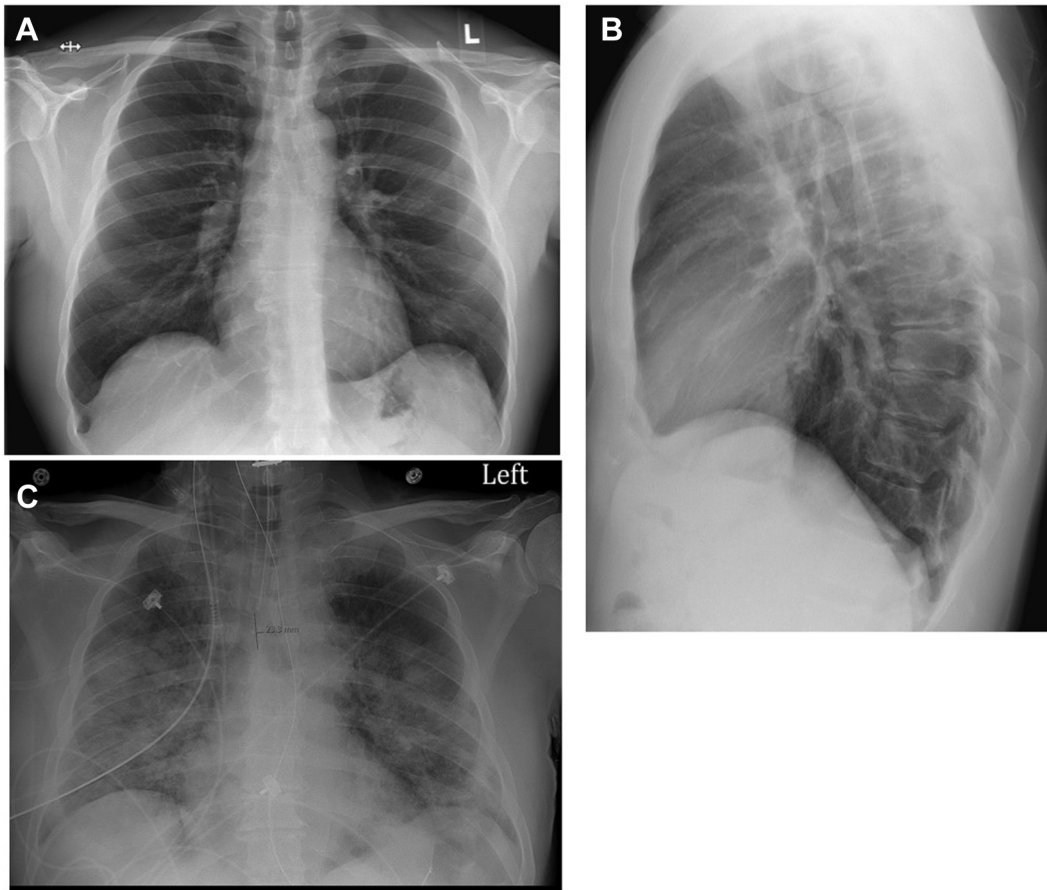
A-C, Chest radiographs at presentation and follow up. A and B, A posteroanterior and lateral view of the chest was obtained after 1 week of symptoms at an outpatient clinic and revealed no evidence of an acute process in the chest. C, Seven days later, a follow-up portable anteroposterior chest radiograph that was performed for worsening symptoms demonstrates multifocal airspace opacities that are consistent with pneumonia.
